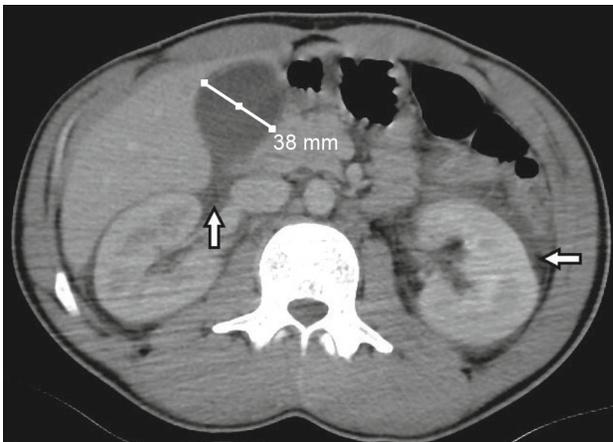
Axial CT of the abdomen shows gallbladder to be slightly hydropic. Bilateral perirenal free fluid is also seen (arrows).
